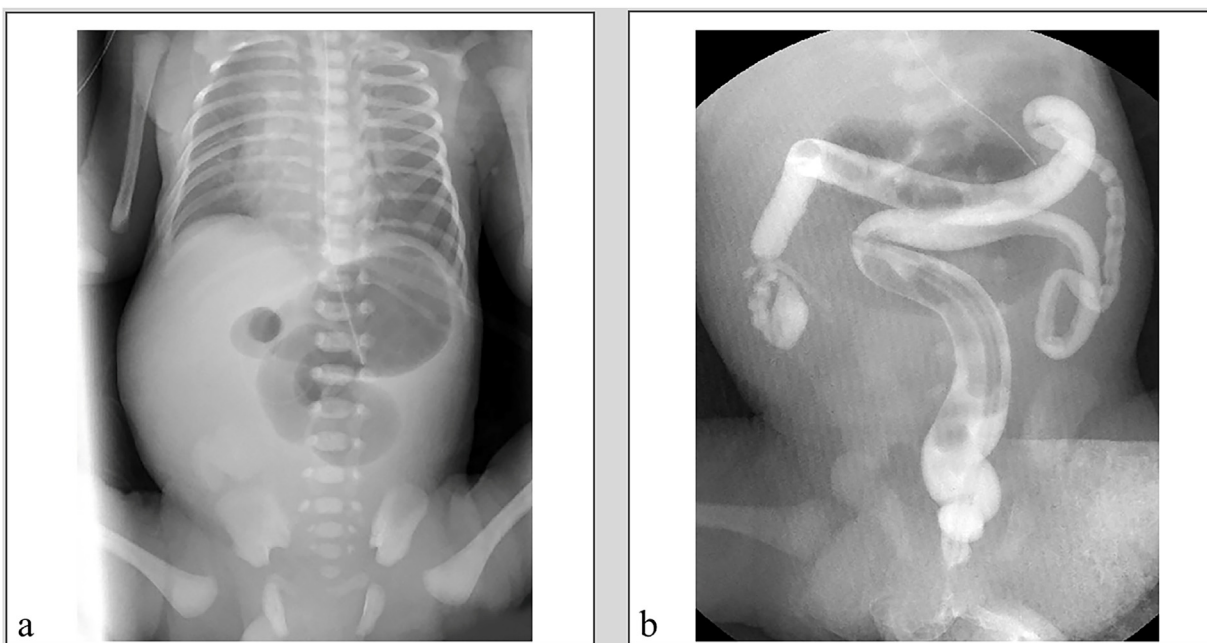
a Abdominal plain radiography shows the dilated upper jejunum. b Contrast-enhanced radiography shows the microcolon.
